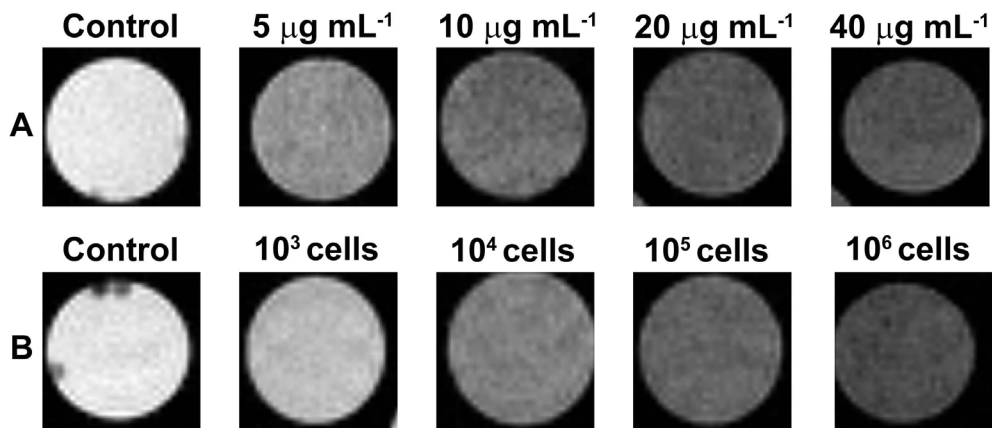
T_2 weighted MR images: HeLa cells incubated with the IONPs-GO hybrids at different concentrations (A) and at different cell densities (B) for 24h. Reprinted from Ref. [16], Copyright 2011 American Chemical Society.
